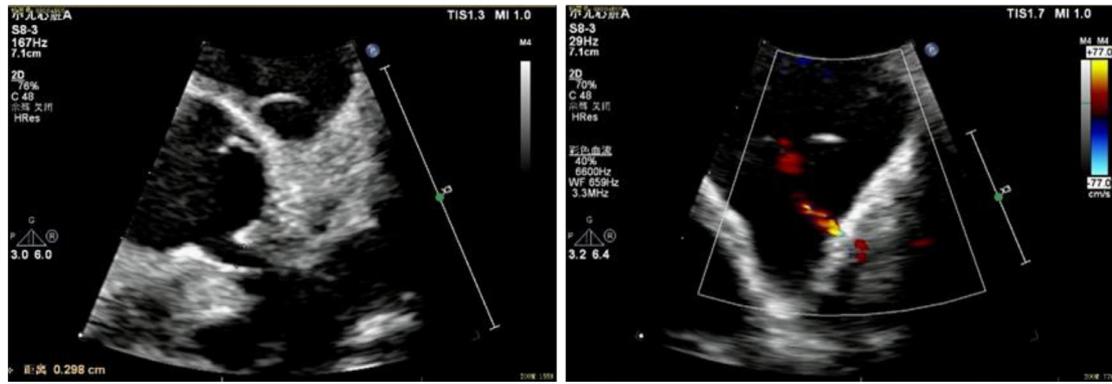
Echocardiography of the heart demonstrates turbulence or eddy flow in the lumen of the main pulmonary artery, and a small left coronary-pulmonary artery fistula was suspected.
